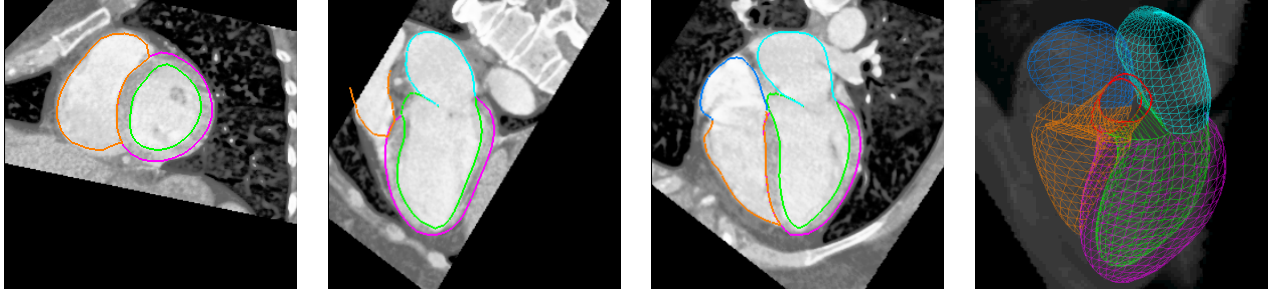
Complete segmentation of all four chambers in a CT volume with green for the left ventricle (LV) endocardial surface, magenta for LV epicardial surface, cyan for the left atrium (LA), brown for the right ventricle (RV), and blue for the right atrium (RA). The first three columns show three orthogonal cuts from the 3D volume data and the last column shows the triangulated surface mesh embedded in the volume.
